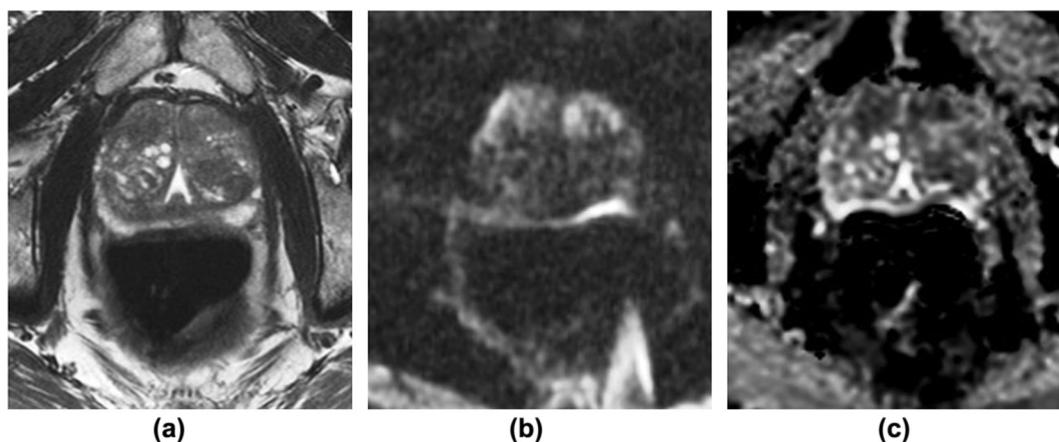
Effect of increased rectal loading. A 64-year-old man with a PSA 4.11 ng/ml, undergoing MRI pre-biopsy. (a) T2 axial image shows marked rectal loading. (b,c) DWI shows warping on $b=1,400$ images (b) and ADC map (c), particularly affecting the posterior gland.
